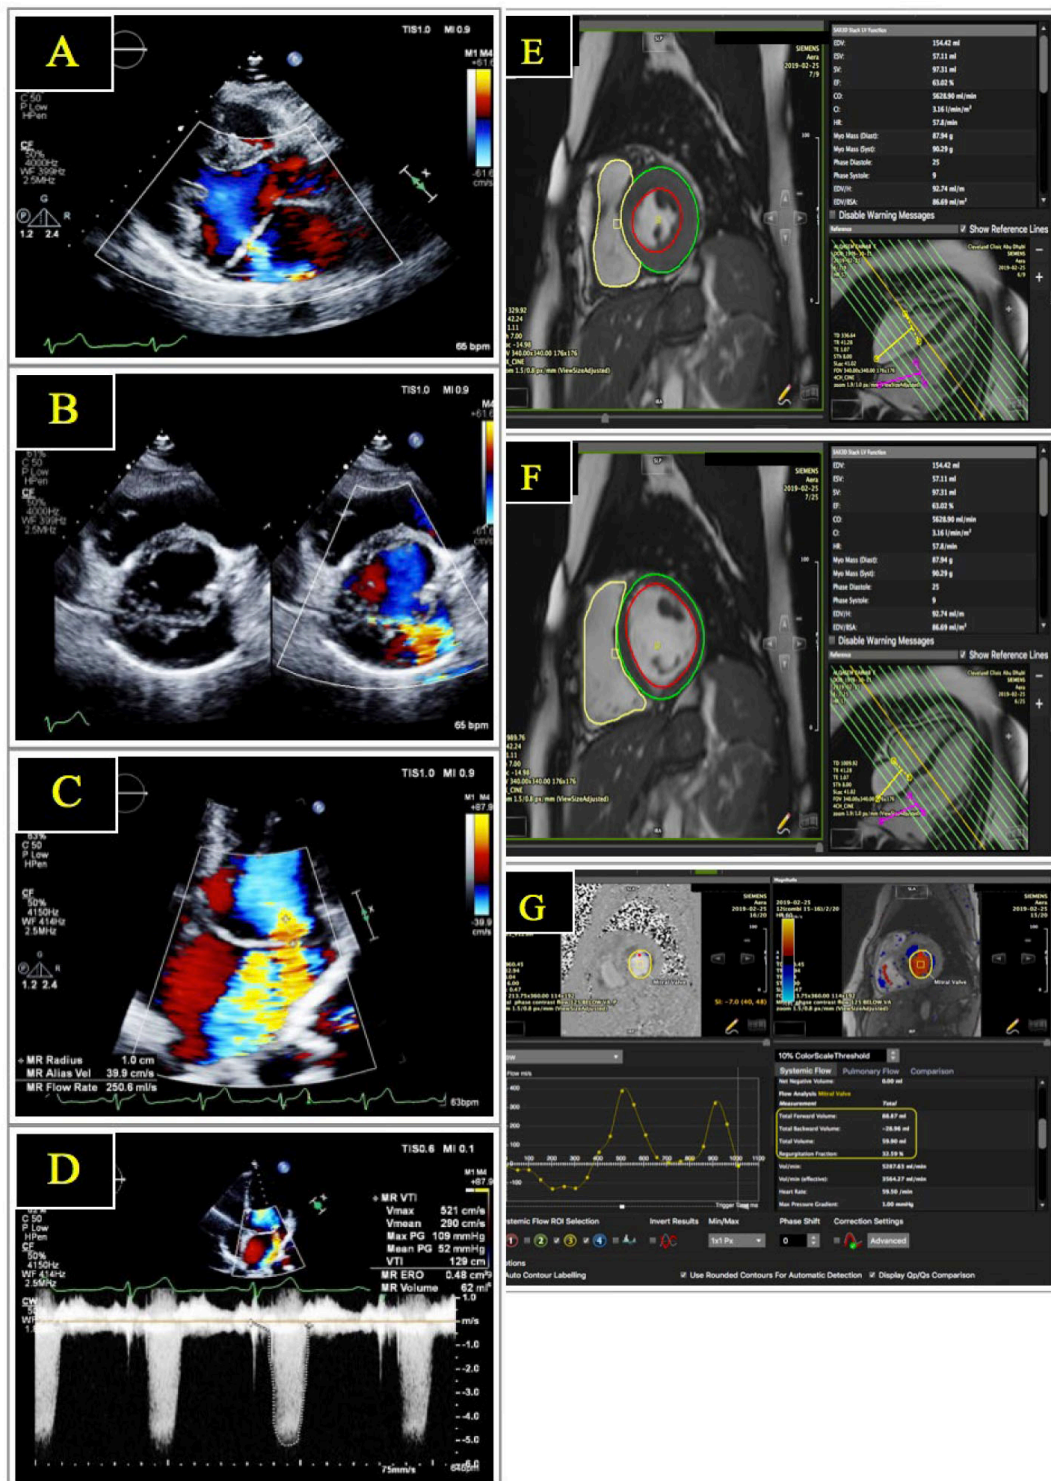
Echo and CMR images of patient with severe eccentric MR. Showing severe primary MR with eccentric jet by echo (Rvol 62 mL, EROA 0.48 cm²) showing excellent correlation with CMR-Rvol₁ (Rvol 59 mL, RF 50%). And moderate correlation with CMR_Rvol₂ (Rvol 28.92 mL, RF 32%). From A to D are Transthoracic echo images showing; (A) Parasternal Long axis view showing MV bileaflets prolapse with posteriorly directed eccentric MR jet. (B) short axis view at basal LV. (C) proximal isovelocity surface area (PISA) MR with radius 1.0 cm, Nyquist limit 39.9 cm/s. (D) Continuous wave (CW) doppler showing Vmax and VTI of MR jet. Form E to G are CMR images showing. (E) Short axis slice showing LV end systolic volume. (F) Short axis slice showing LV end diastolic volume. (G) Phase contrast velocity encoding (VENC) showing total forward flow (mitral valve stroke volume = 88.87 mL), Flow reversal (CMR_Rvol₂=28.92 mL).
